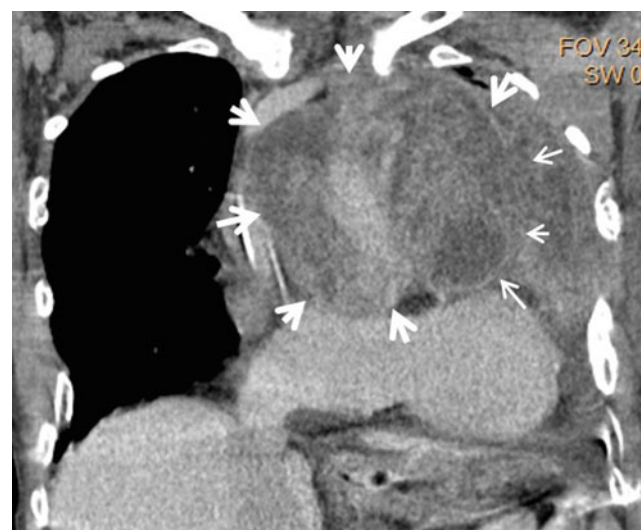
CT pulmonary angiogram (coronal plane) shows a tumor (arrows) surrounding the heart and large vessels
